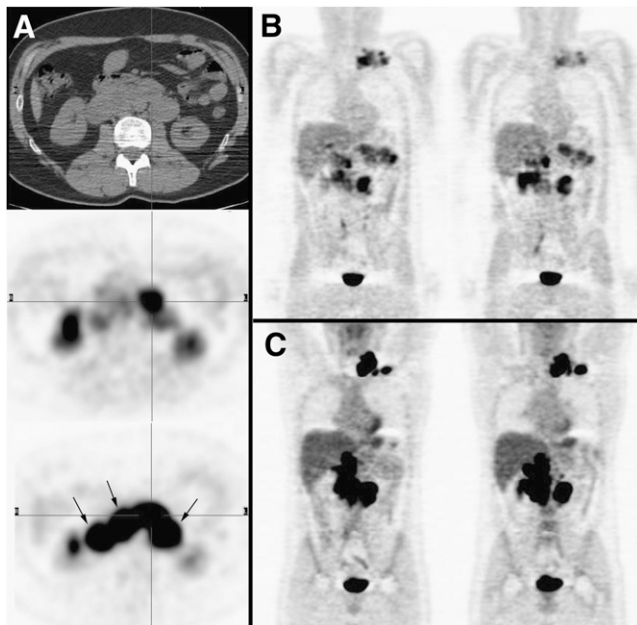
Metastatic SDHB-related pheochromocytoma (patient 27): multiple abdominal paraganglioma seen on axial CT (top), axial $6\text{-}^{18}\text{F}$ -fluorodopa PET (middle), and axial ^{18}F -FDG PET (bottom) (A); $6\text{-}^{18}\text{F}$ -fluorodopa PET (coronal whole-body axial images) (B); and ^{18}F -FDG PET (coronal whole-body axial images) (C). Compared with $6\text{-}^{18}\text{F}$ -fluorodopa PET, ^{18}F -FDG PET detected additional tumor sites and ^{18}F -FDG PET avidity was higher (arrow).
